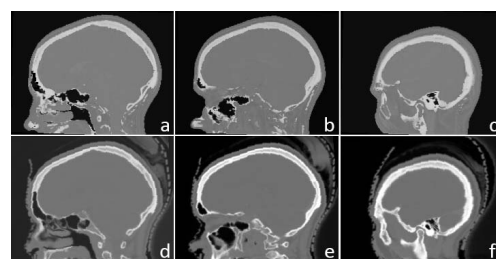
SynCT (a-c) and treatment planning CT (d-f) of patient data highlighting the close agreement of bone and air visualization between image types.
